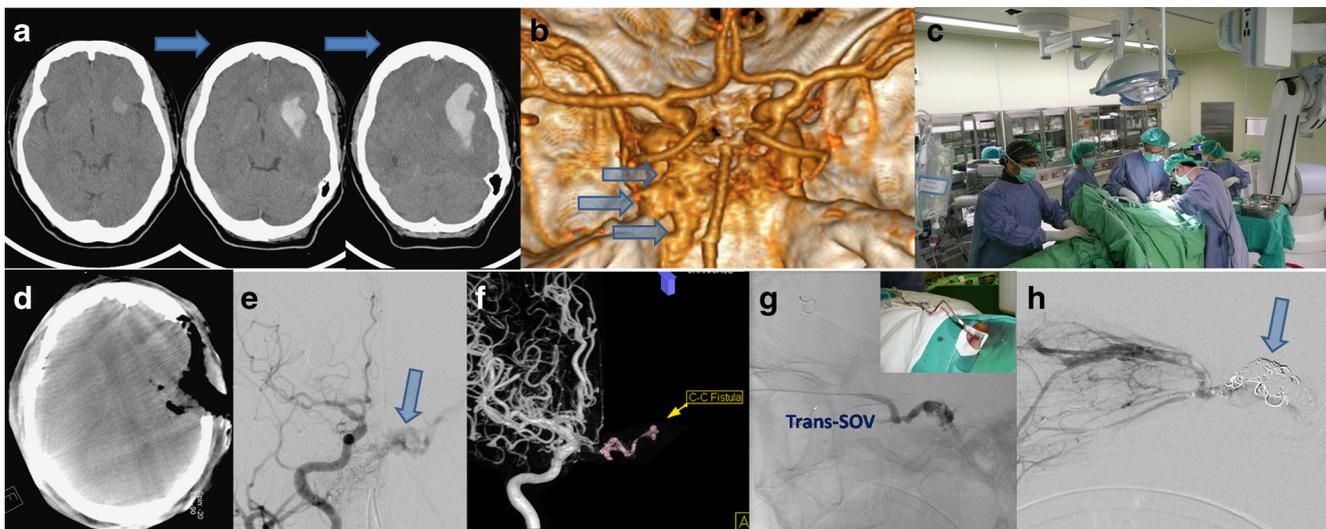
A type-D CCF with venous hypertension and ICH treated in the hybrid OR. (Level A) a Serial brain CT scans showed ICH progression with mass effects. b 3D CT angiography showed abnormal and enlarging left cavernous sinus (blue arrows). c A craniotomy for ICH removal and decompression was performed. Simultaneously, a femoral approach was prepared for DSA. Of note, we parked the robotic arm (in the upper right corner of this picture) away from the operative field to avoid contamination and offer more space for surgeons. d Intra-operative Dyna-CT was
